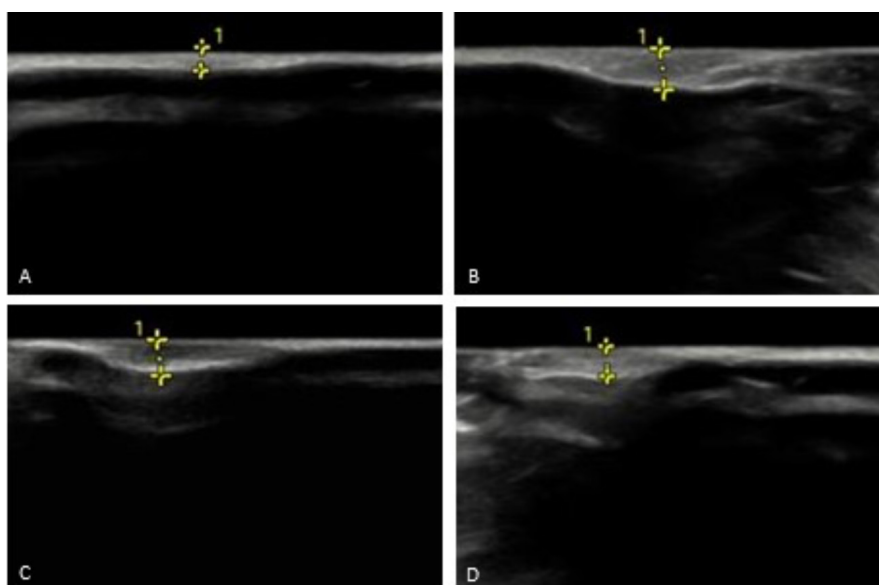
Ultrasonographic images of the skin. (A) Control group, (B) BLM group, (C) BLM+IXE group, and (D) BLM+MMF group.
